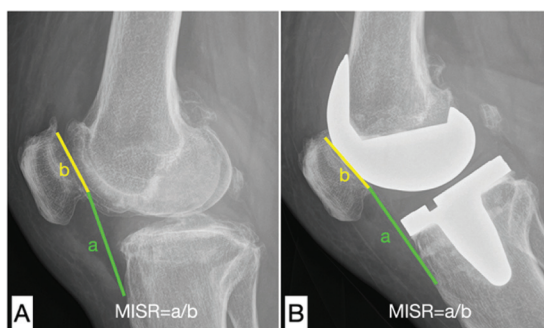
Radiographic measurements and calculations of patellar height using the modified Insall-Salvati ratio (MISR) method. (A) Preoperative radiogram, (B) Three months post-operative radiogram.
